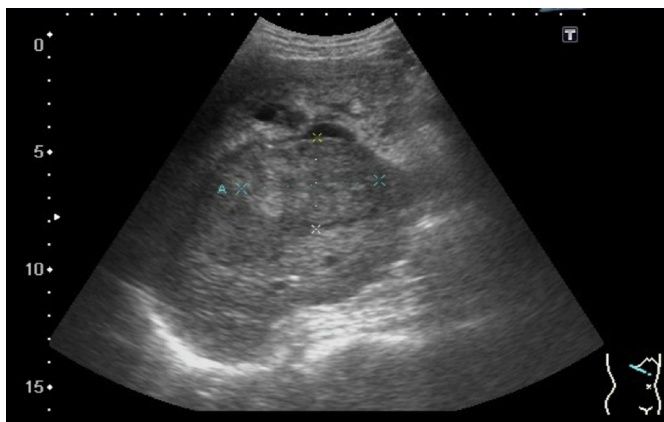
Abdominal sonography showing a 5.9×3.9 cm heterogeneous mass in segments 5–7 of the liver.
